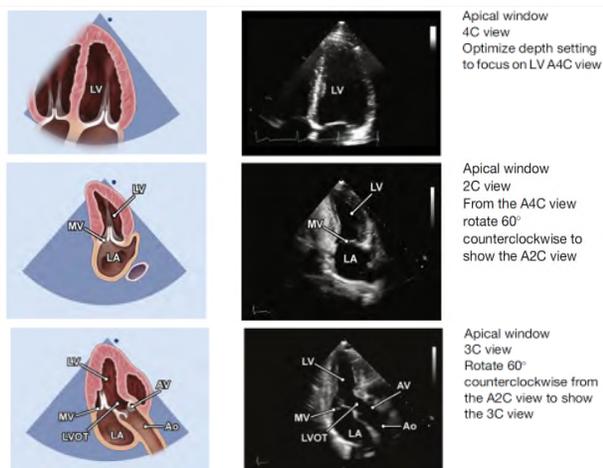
Apical 4C, 2C and 3C views.
